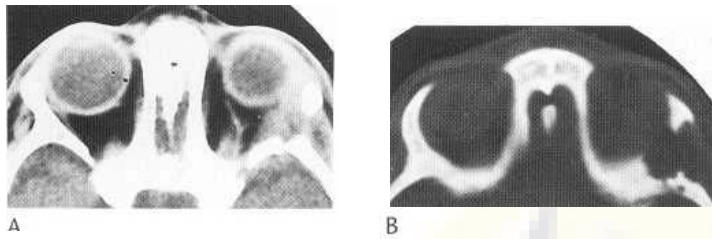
Histiocytosis. Axial CT image (A) demonstrates soft-tissue mass in superolateral aspect of left orbit. Bone window (B) shows associated bony erosion.
